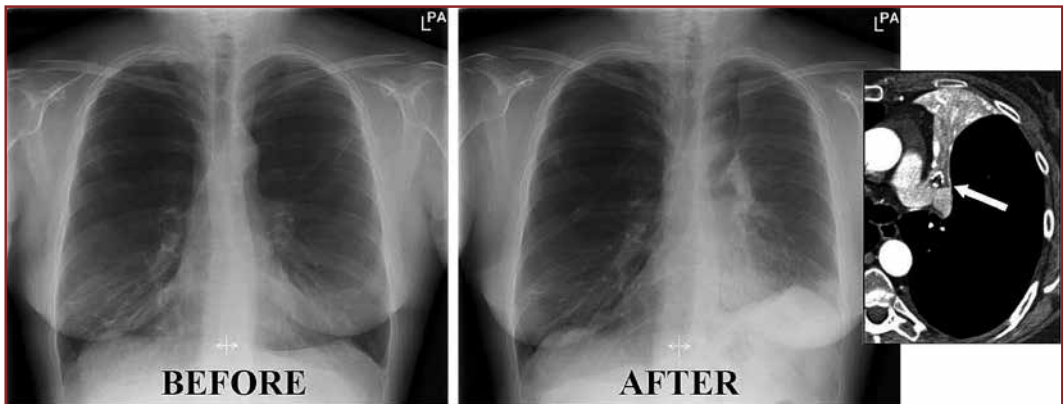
X-ray before and after EBV treatment and visible atelectasis after treatment on HRCT
